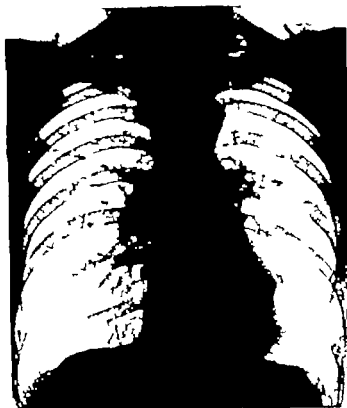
(a) — Radiograph showing emphysema of left lower lobe associated with a left perihilar mass. There is absence of vascular marking when compared with right lower lobe. Symptoms were of dyspnoea and haemoptysis and bronchoscopy showed a tumour partially blocking the lower lobe.
